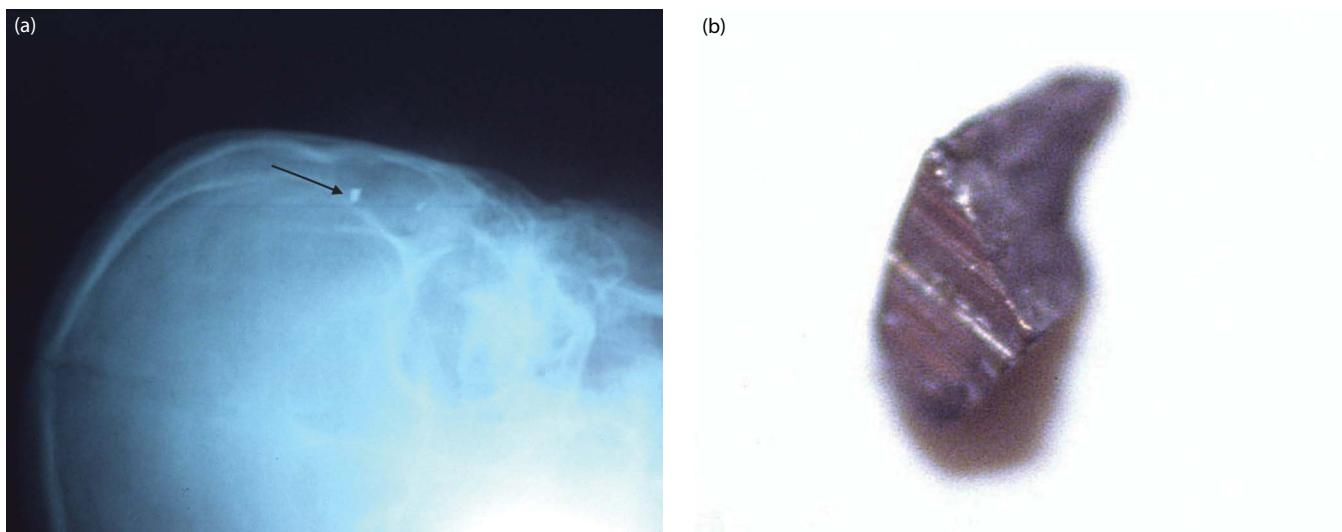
Scissor fragment in skull. Radiographs are not only for gunshot wounds. (a) In this x-ray of a stabbing victim, a small metallic fragment can be seen in the middle of the figure as a white dot near the top. This victim was stabbed with a scissors, part of which broke off in the skull. The small fragment was removed at the autopsy. (b) Knife tips can break off when hitting bone as well. The broken fragment can be matched to a purported weapon.
